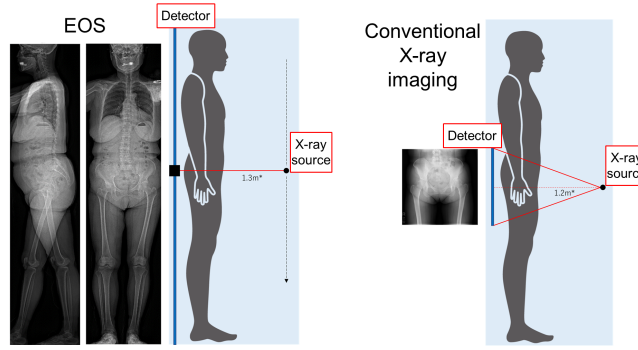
Differences between the EOS imaging system and conventional X-ray imaging. Conventional X-ray imaging emits radiation radially from a fixed X-ray source, whereas the EOS imaging system uses a moving source to emit radiation horizontally, enabling full-body imaging.
